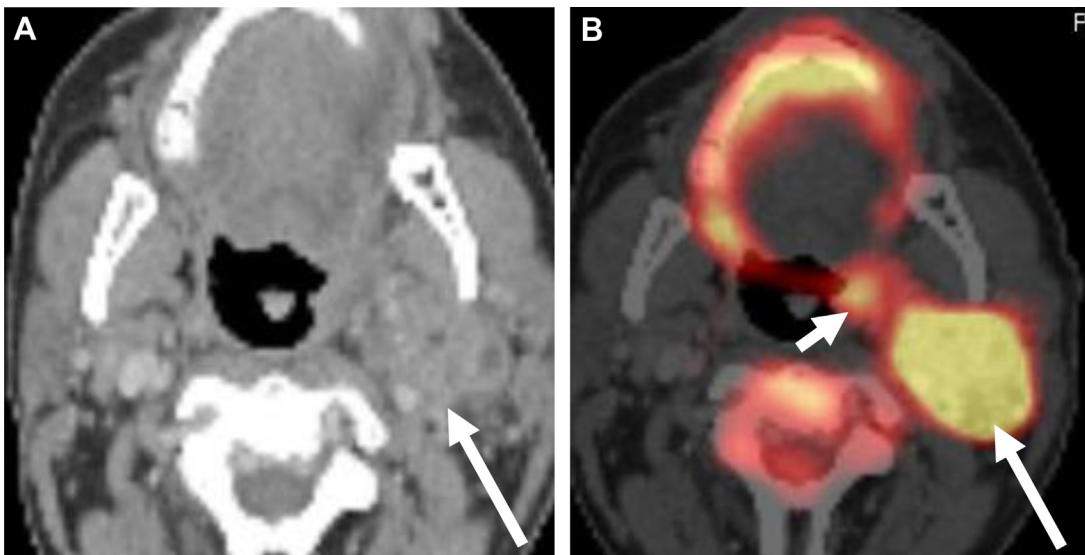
Unknown primary detected with PET-CT. (A) Axial contrast-enhanced CT shows a large left level II nodal mass which was biopsy-proven SCC (arrow). No tumor was identified on direct endoscopy. The patient was thought to have an unknown primary and underwent PET-CT in an attempt to localize the tumor and help direct speculative biopsies. (B) PET-CT shows uptake in the large left nodal mass (long arrow) and focal uptake in the left tonsil (small arrow), which was suspicious for a left tonsillar carcinoma. The patient underwent a left tonsillectomy, which confirmed the diagnosis of a left tonsillar carcinoma, which was initially felt to be an unknown primary cancer eventually detected by PET-CT.
